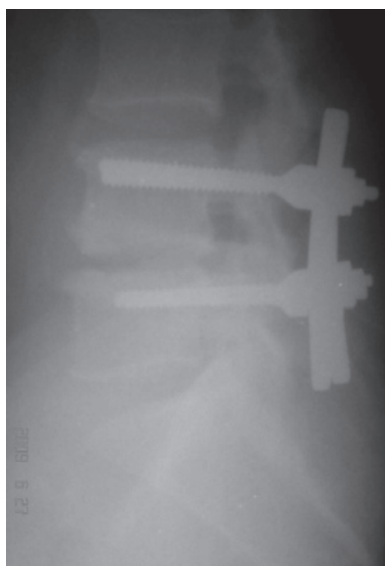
Postoperative lateral lumbosacral x-ray, showing pedicle screws and plate system inserted on L4-5 level
